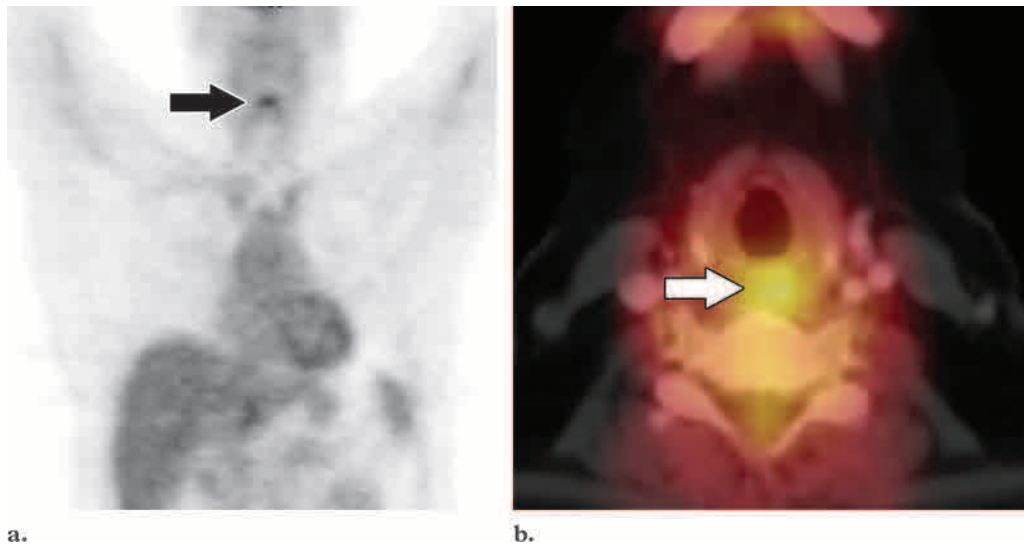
Physiologic cricopharyngeus muscle uptake. (a) Coronal PET scan demonstrates a hypermetabolic focus (arrow). (b) Axial fused PET-CT scan helps localize the area of uptake precisely to the cricopharyngeus muscle (arrow).
